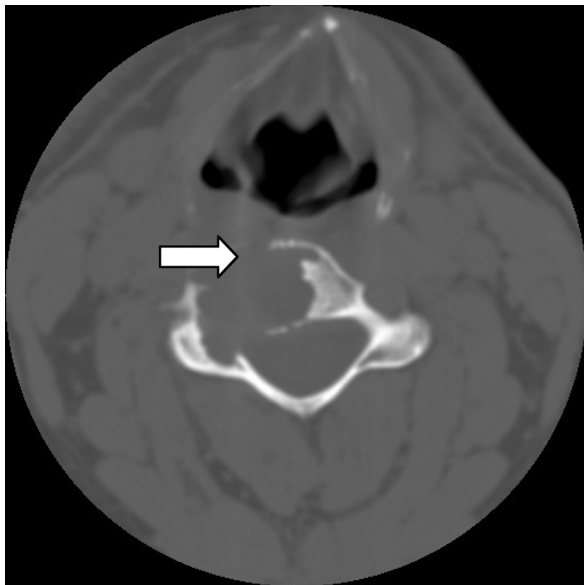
CT image with bone window that shows an osteolytic lesion involving C4 right portion.
